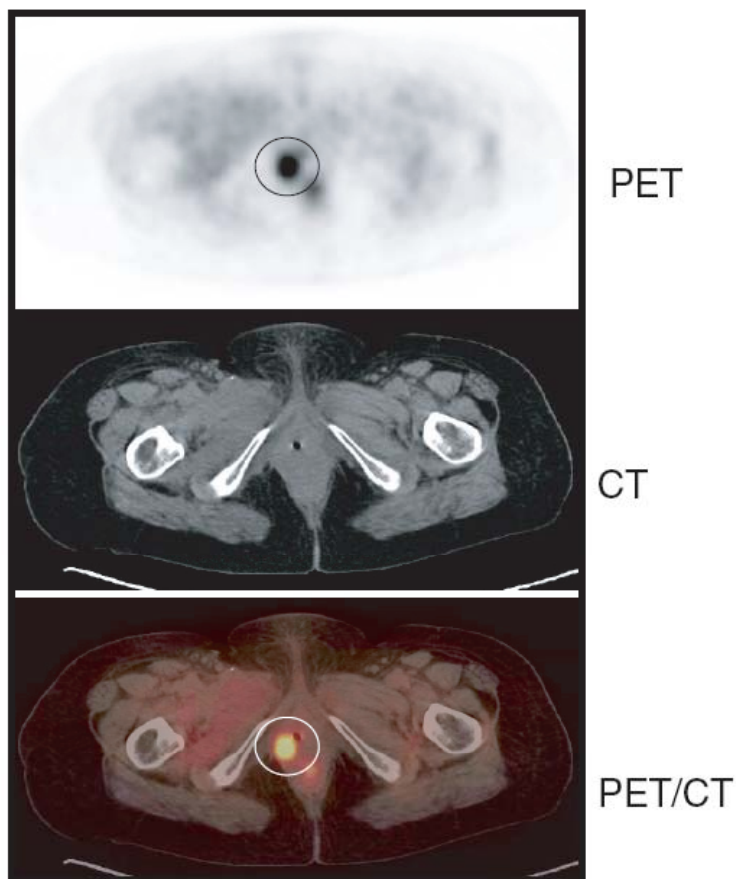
PET, CT, and PET/CT images of a patient with cervical cancer, undetected except on the PET images. (The circles highlight the focal area of FDG uptake, indicative in this case of cervical cancer, on the PET image and the PET/CT overlay image, but no abnormality is seen on the standard CT image.)
